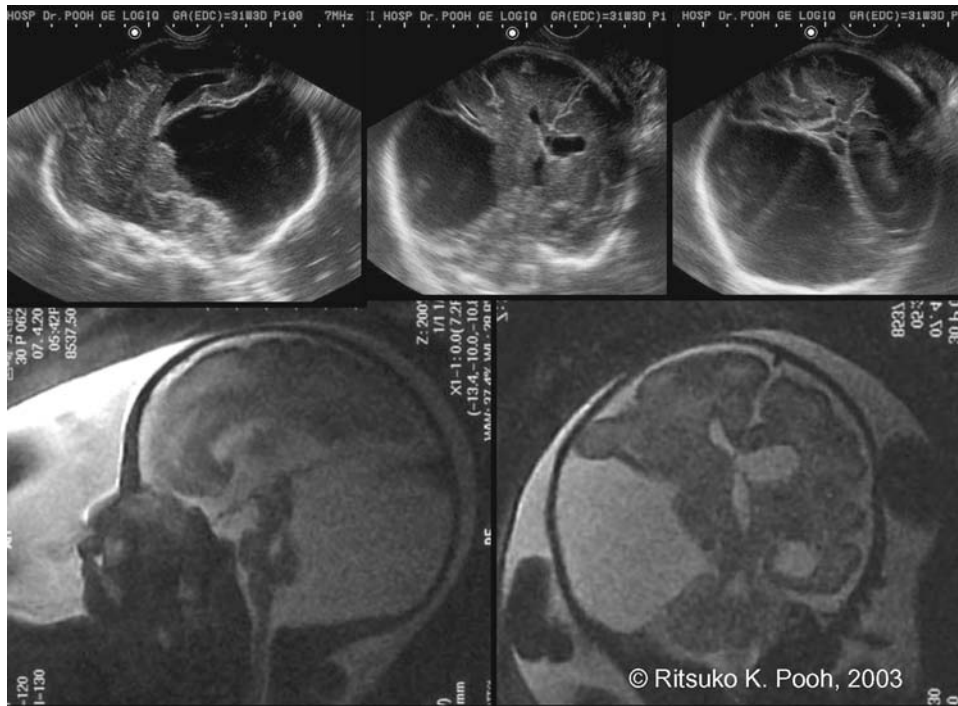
Fetal arachnoid cyst at 31 weeks of gestation. (Upper) Transvaginal ultrasound image. Sagittal (left) and coronal (middle, right) sections. (Lower left) Fetal MR sagittal image. The cyst occupies supra- to infratentorial space. Not only cerebrum but also the cerebellum is compressed by the cyst. (Lower right) Fetal MR coronal image. Midline is conspicuously arcuated. Unilateral scalp and skull bone are extended due to the existence of the huge cyst. Note the difference between right and left head size.
